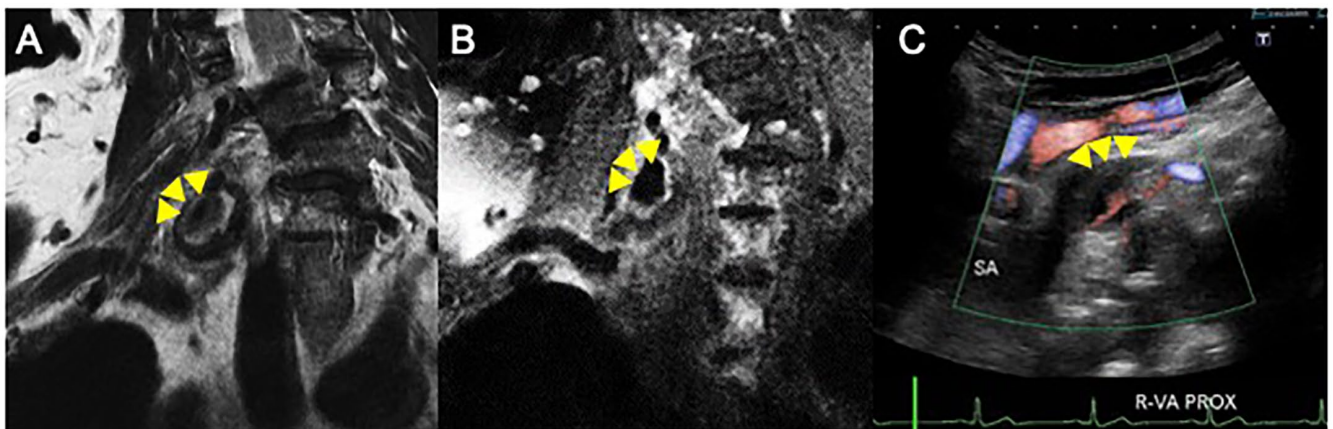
MRI T1 (A) and T2-weighted coronal images (B) showed a low intensity into the aneurysm suggested thrombotic change. (C) Ultrasound sonography also showed thrombotic change as low echo signal at the ventral side of aneurysm (yellow arrow heads).
